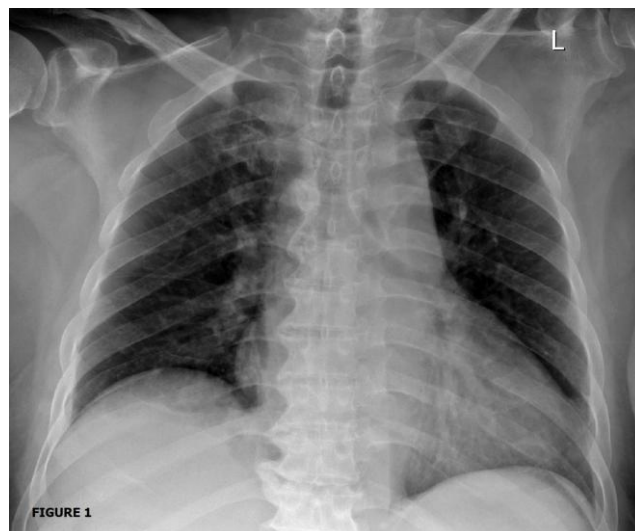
Chest X-ray is taken a few hours after arrival showed minimal consolidation over the right lower zone
